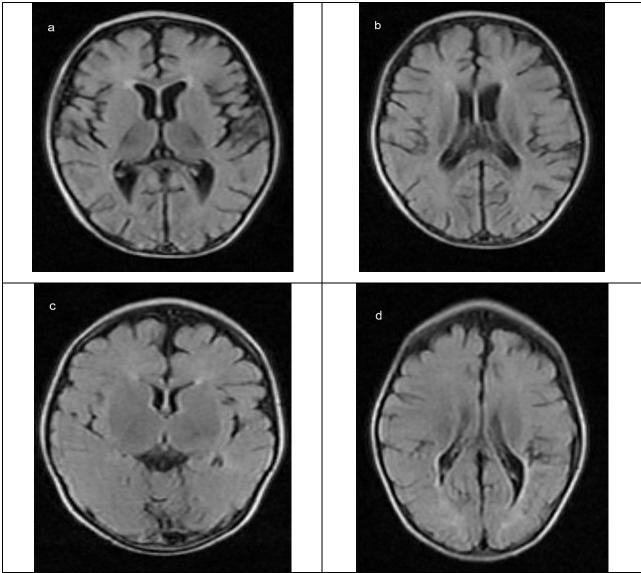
Axial FLAIR MR images at the level of the basal ganglia. a and b 10 months old patient on admission showing mild brain atrophy in the form of dilated ventricles and prominent cortical sulci. c and d follow-up MRI of the same patient at day 90 after treatment showing resolution of the signs of cerebral atrophy with normal ventricular size and cortical sulci.
